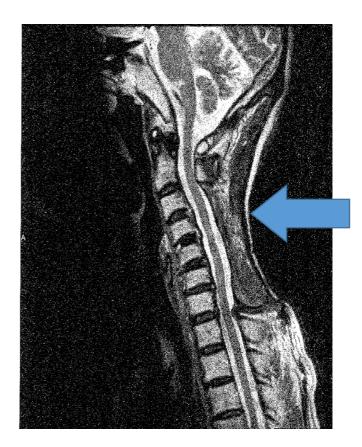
Case 3, CT image after first surgery: The muscle is largely gouged
